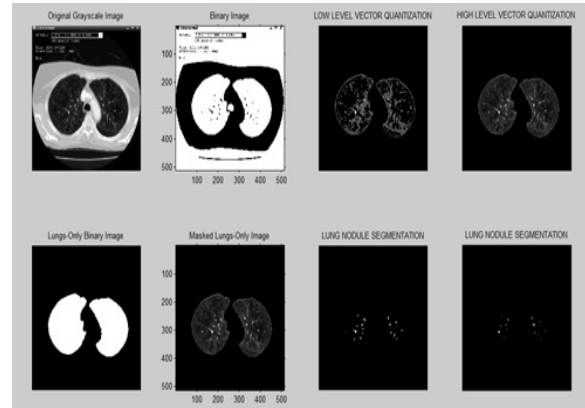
Normal lung CT images
